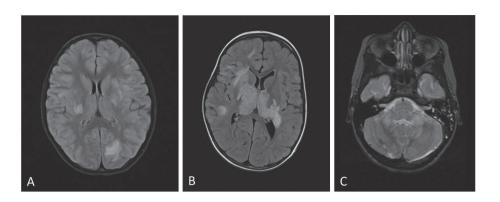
MOG-IgG associated MRI abnormalities. Figure 1.4A and 1.4B: supratentorial large confluent white matter abnormalities, some are poorly demarcated. 1.4C: white matter abnormalities in the bilateral cerebellar peduncles.
